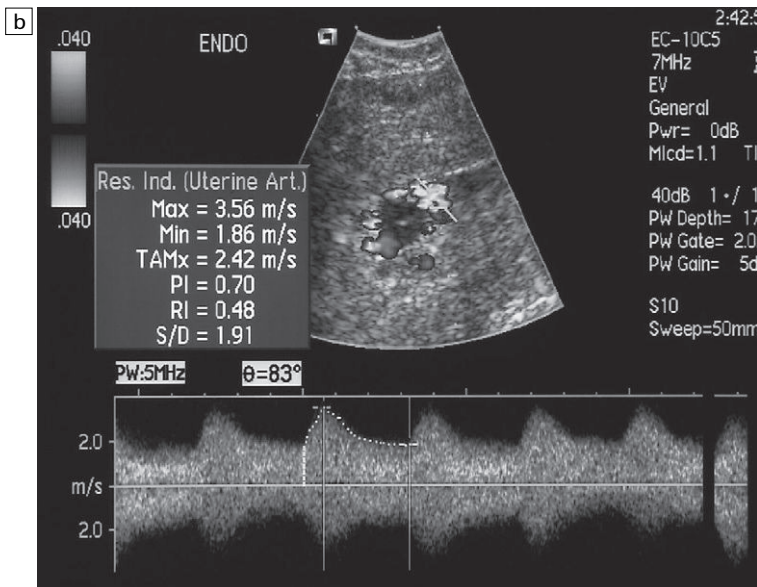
Retained products of conception: (a) demonstrates residual trophoblast within the uterine cavity; (b) colour flow (depicted in black and white) demonstrates disordered pattern while spectral Doppler yields a low resistance pattern.
